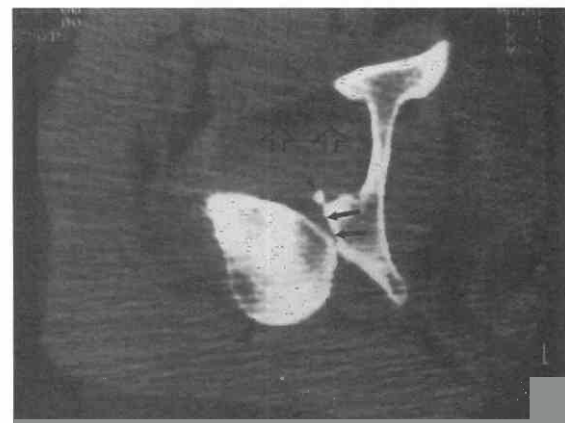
Posterior column fracture with dislocation in a 30-year-old man after a motor vehicle accident. CT scan shows the femoral head posteriorly dislocated (*large arrowheads*), with small intra-articular fragment (*small arrowhead*), fractured posterior column (*large arrows*), and lipohemarthrosis in the joint (*open arrows*).
